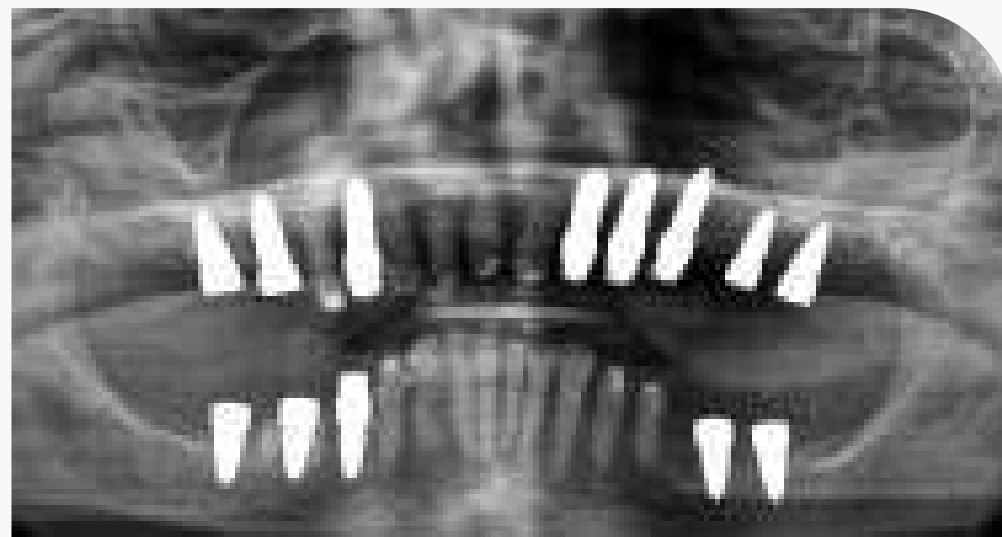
Immediate loading of the SDS implants: (A) The orthopantomography showed the final position of the implant placement; (B) 24 h after surgery: the elegant and precise provisional adapted to the gingival situation and the coronal shape of the SDS implants at the tissue level.
